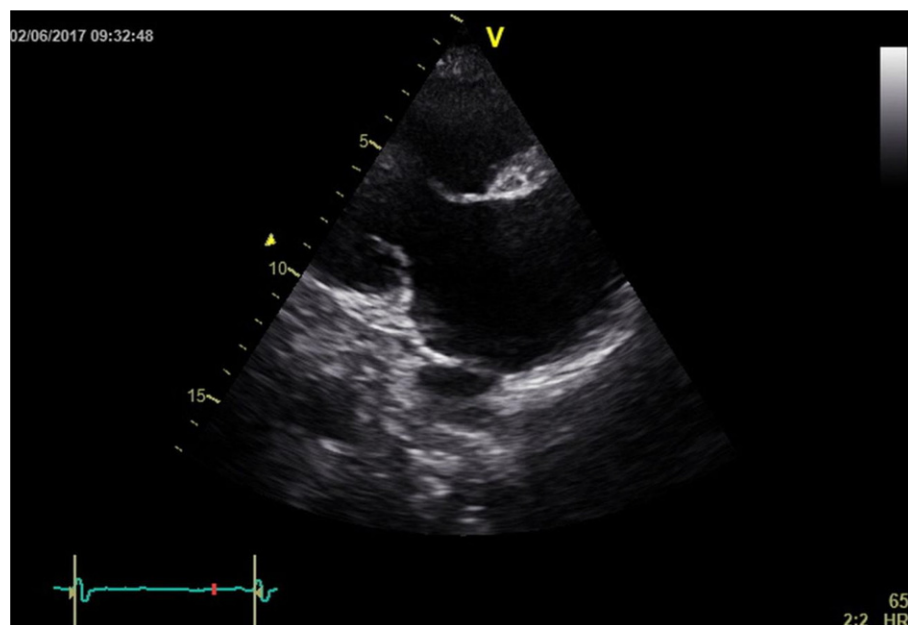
Transthoracic echocardiogram showing thickened and rigid tricuspid valve leaflets in a patient with CS.
